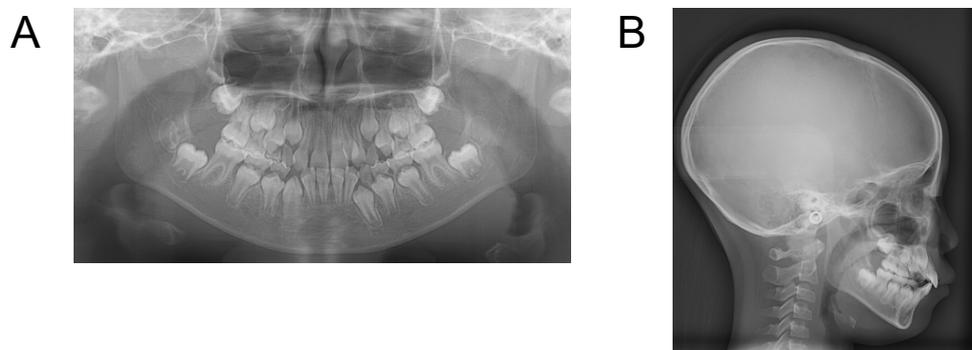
Panoramic radiograph (A) and lateral roentgenographic cephalogram (B) of Case 3 at initial examination.
